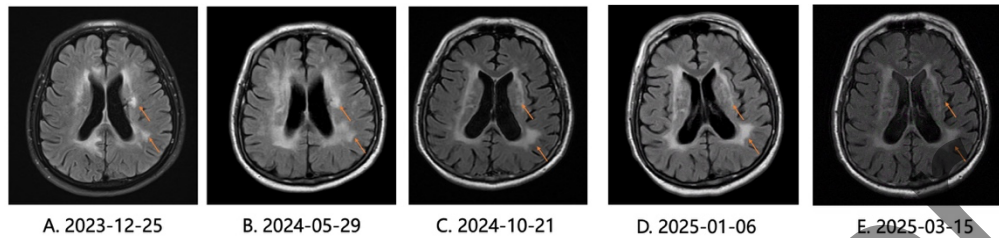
Sequential brain MRI findings during treatment with limerlisib. (A), brain MRI on 25th, Dec, 2023: yellow arrow showed tumor relapse. (B), brain MRI on 29th, May, 2024: decreased signal intensity of the relapsed tumor. (C), brain MRI on 21st, Oct, 2024: further reduction in size and signal intensity of the lesion. (D), brain MRI on 6th, Jan, 2025: decreased size and signal maintained. (E), brain MRI on 15th, Mar, 2025: lesion size and signal remained stable at the reduced level.
